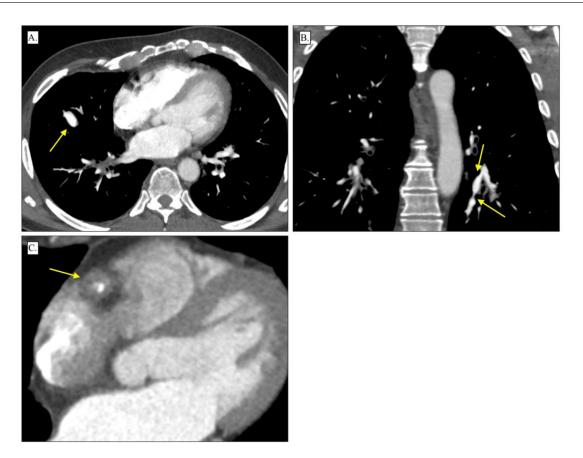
Contrast-enhanced chest computed tomography images for patient 2. Axial and coronal images demonstrate subsegmental pulmonary arterial dilatation (arrows) within the right middle (A and B) and lower lobes. Other less conspicuous foci of dilatation not shown. (C) Contrast-enhanced chest computed tomography images for patient 2 show soft thickening around the right coronary artery (arrows).
